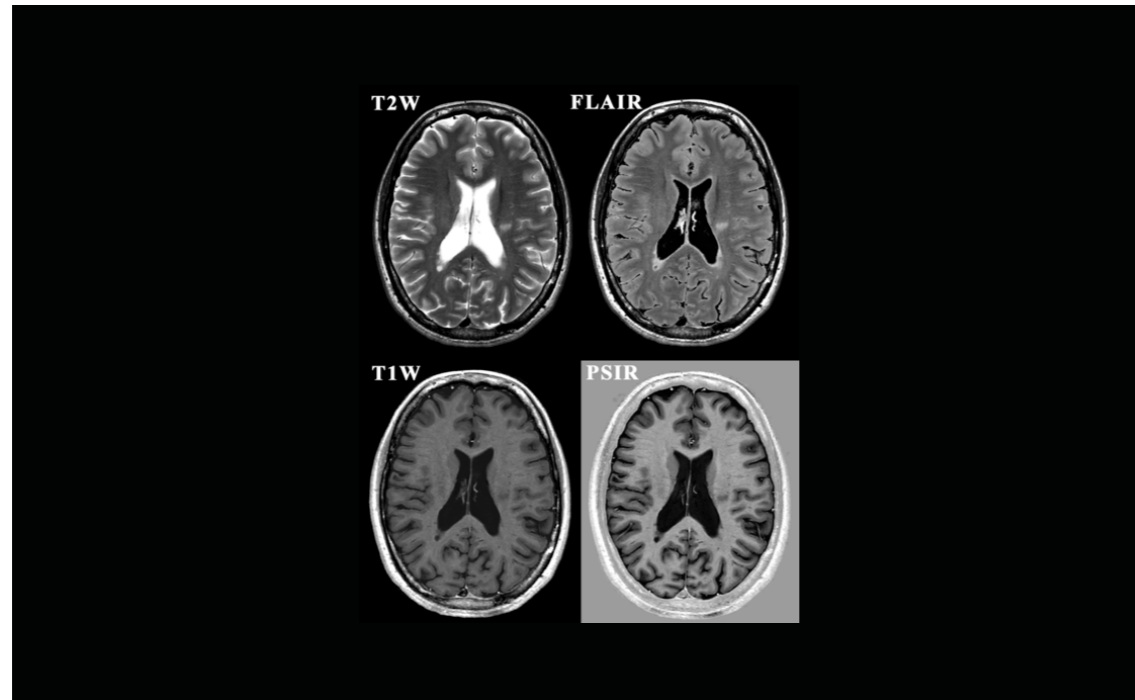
Examples of SyMRI® images, all based on the T1, T2 and PD maps of Fig. 2. There are FSE images such as T1W and T2W and IR-FSE images such as the FLAIR and PSIR images.
